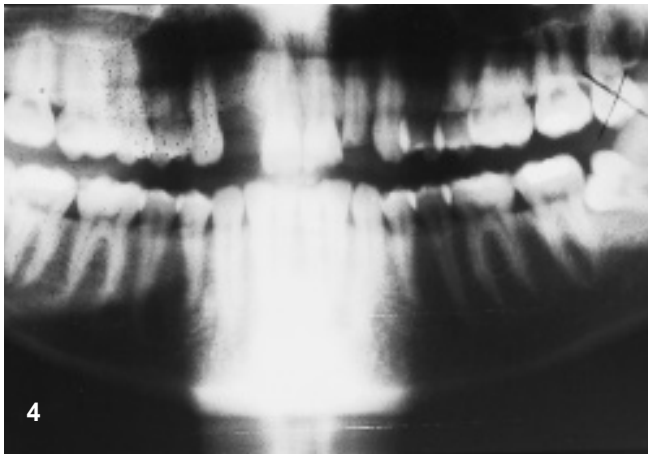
Panoramic radiograph taken in 1993 of a 26 year old patient with hepatitis C infection.
